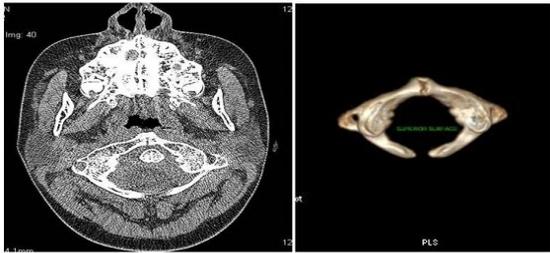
Bipartite atlas in a 12 year old boy CT a.axial view b.Three dimensional view.
